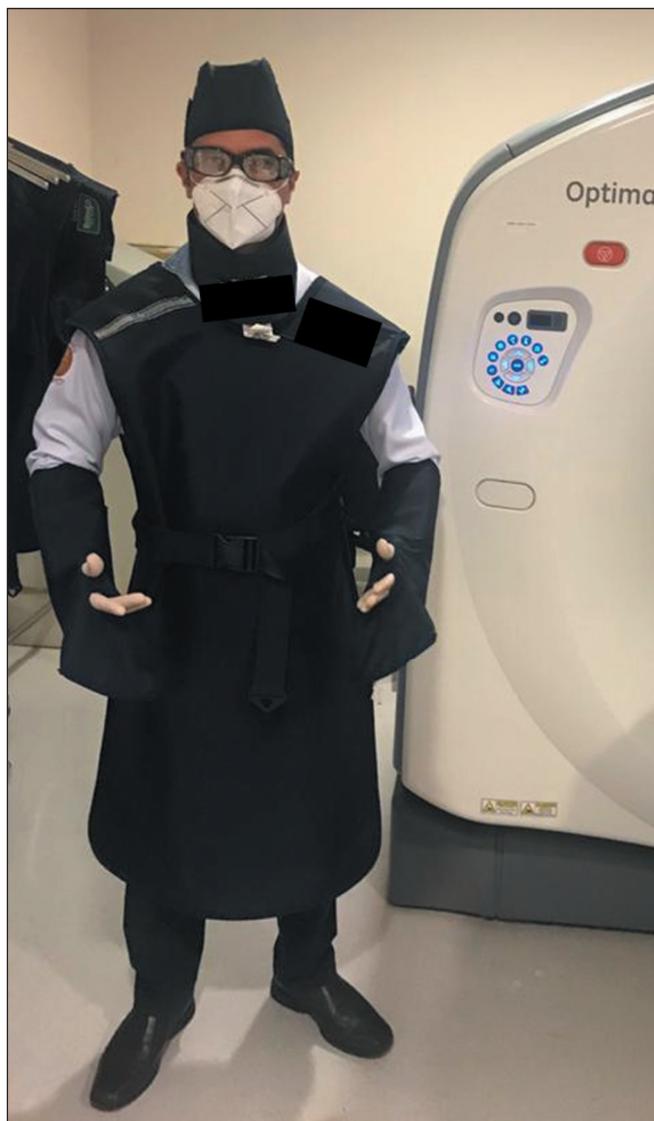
Example of personal protective equipment for radiation protection, demonstrating the preparation of the physician-operator (interventional radiologist) for CT fluoroscopy-guided biopsy procedures: lead cap, eyewear, thyroid protection, lead apron, and gloves.
